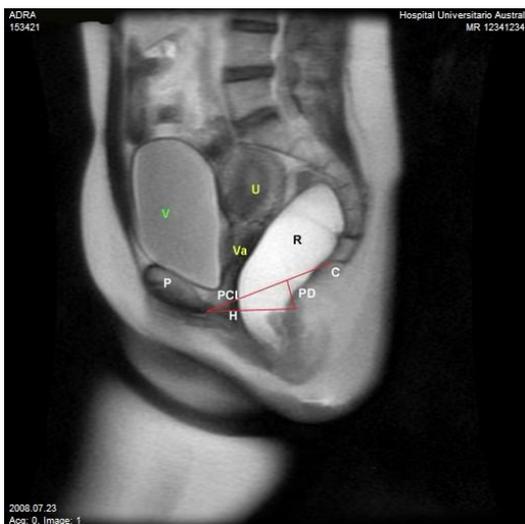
Dynamic MRI of the pelvic floor. P: Pubis. V: Bladder. U: Uterus. Va: Vagina. R: Rectum. C: Coccyx. PCL: Pubococcygeal line. PD: Pelvic floor descent line, also referred to as M line. H: Puborectal hiatus line.
